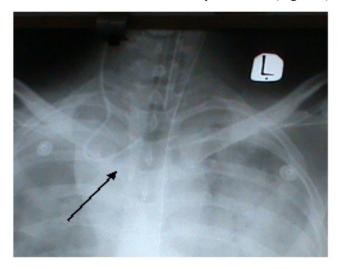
X-ray shows vascular injury with widening of mediastinum (haemomediastinum).
